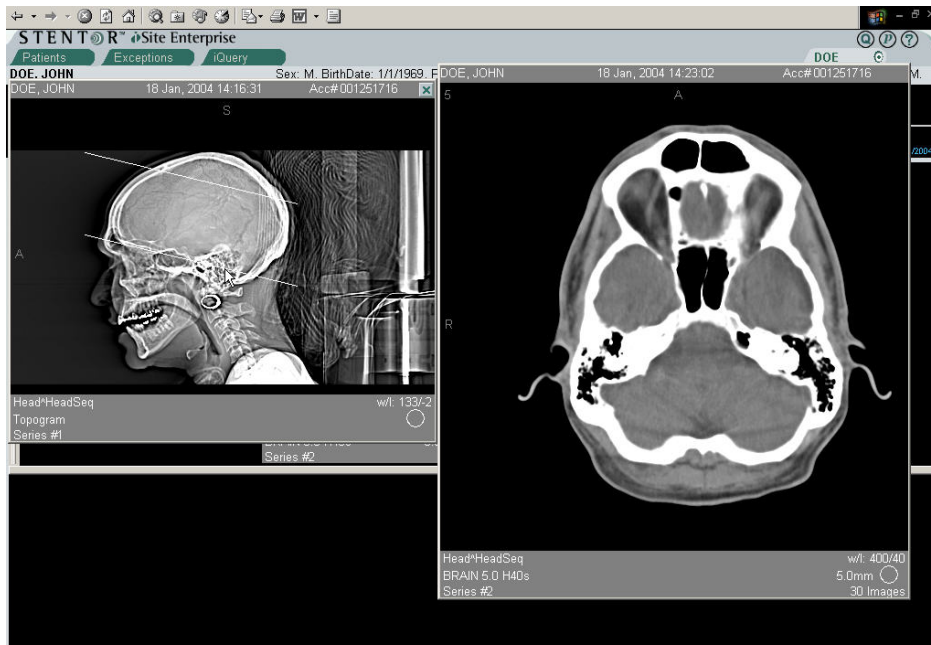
An example of MRI images at the Web browser.
